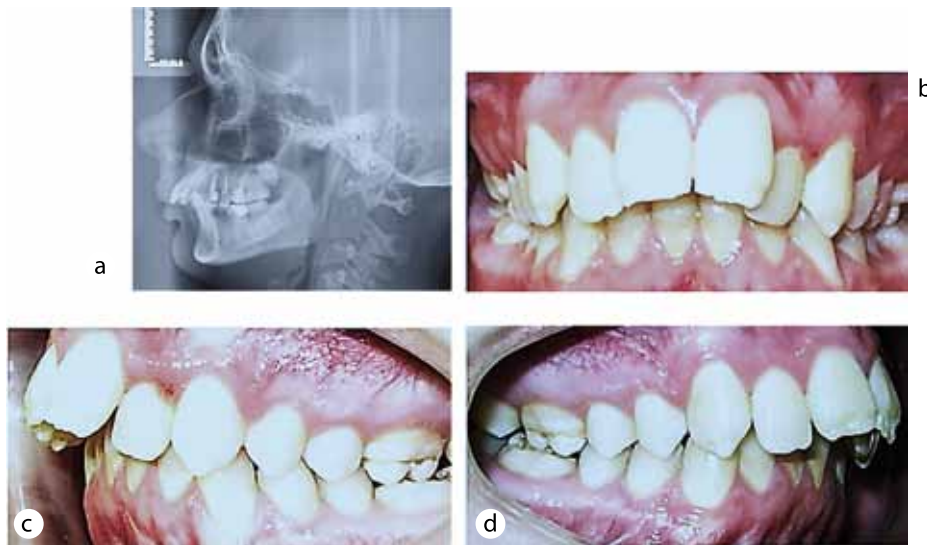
X-ray and photographic features of dental system, patient M., 15 y.o., with severe CTD. Head telorentgenogram, lateral projection (a), pathological occlusion (b — direct projection, c — left-side lateral projection, d — right-side lateral projection)
